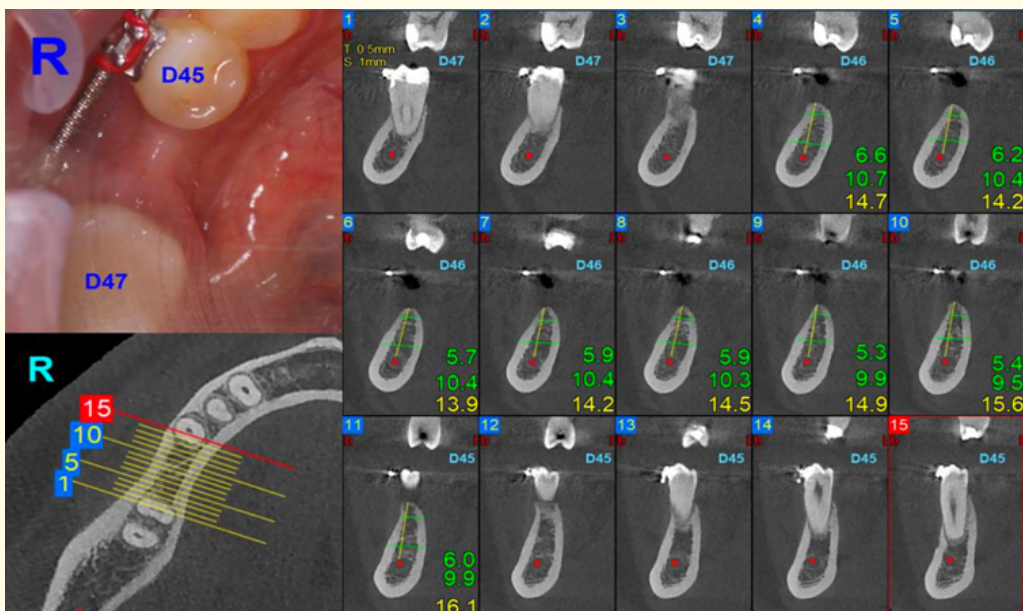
The CBCT imaging of the right side.
